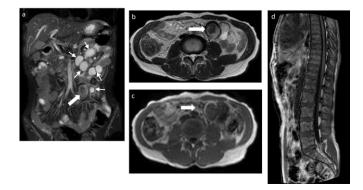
A: Coronal Short tau inversion recovery (STIR) image shows multiple fluid signal intensity (T2 hyperintense) cysts in the mesentery in the left hypochondrium and lumbar region (arrows), showing conglomeration. Few of the cystic lesions were mixed signal intensity on STIR (solid arrow). B: Axial T2-weighted (T2W) MR image shows heterogeneous signal with hypointense rim, suggesting haemorrhage within the cystic lesion. C: Axial T1W MR image depicts hyperintense periphery, indicative of hemosiderin. D: Sagittal T1W MR image depicts heterogeneity within the vertebral marrow with multiple tiny ill-defined foci of mild T1 hypointensity, suggesting marrow reconversion.
